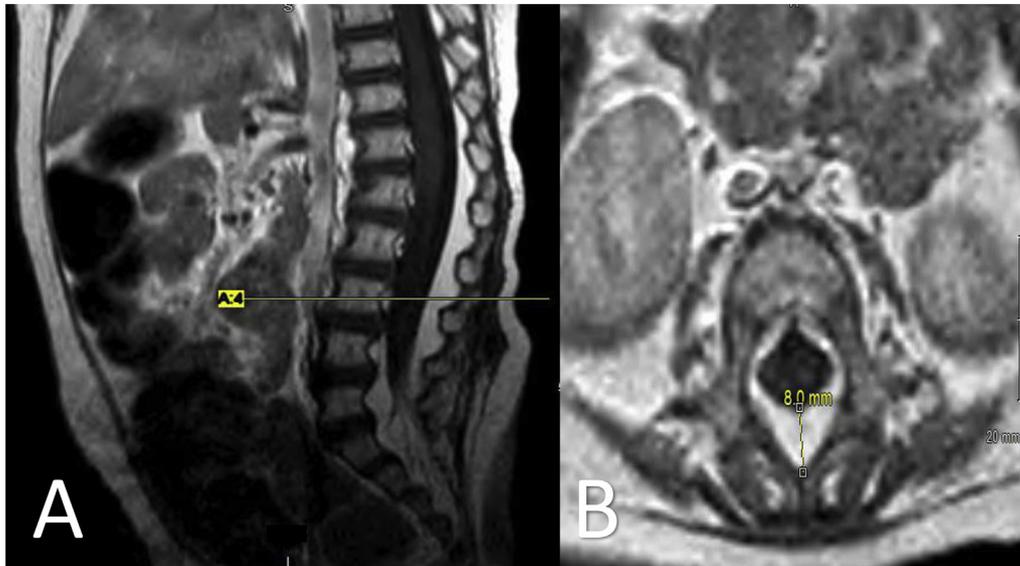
Magnetic resonance imaging of the spine. T1-weighted sagittal view (A) and axial view from the level of the horizontal line (B) demonstrating diffuse spinal epidural lipomatosis with maximum thickness 8 mm across the lumbar spine (represented by the yellow line across corresponding sections of L2 vertebra), without thecal sac compression. The color version of this figure is available in the online edition.
